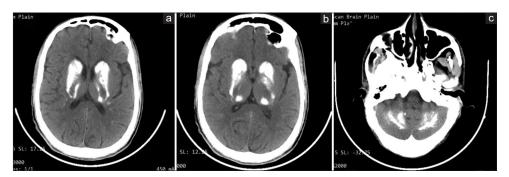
(a-c). Brain non-contrast computed tomography (CT) showed bilateral symmetrical calcification in the basal ganglia, thalamus and cerebellar hemispheres
